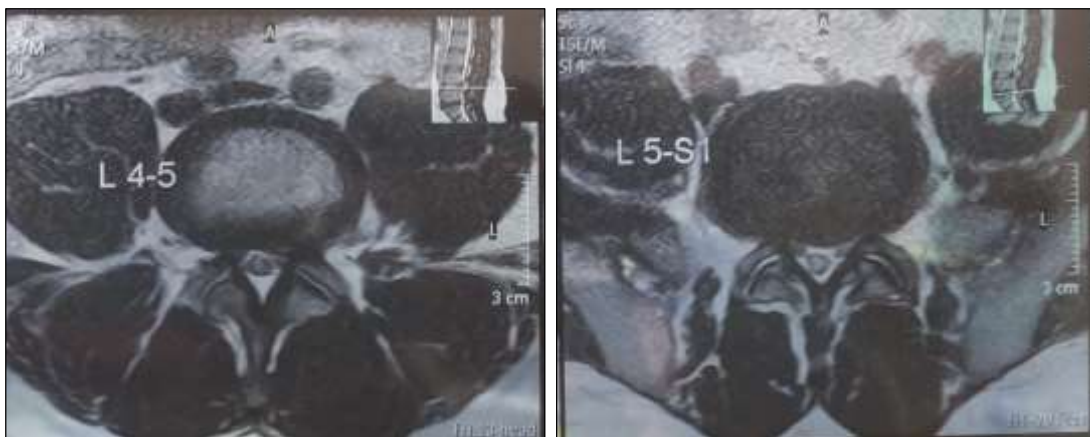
Previous MR image
